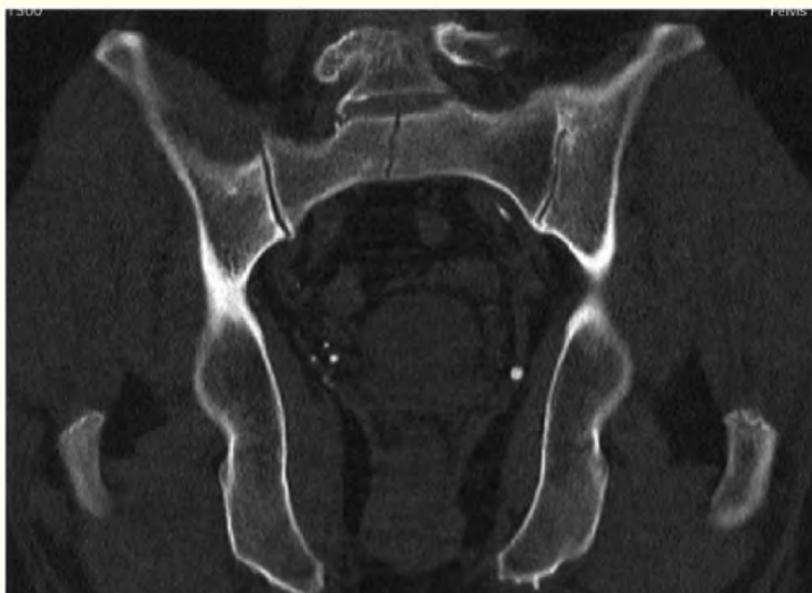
Pre-operative CT (coronal plane).
